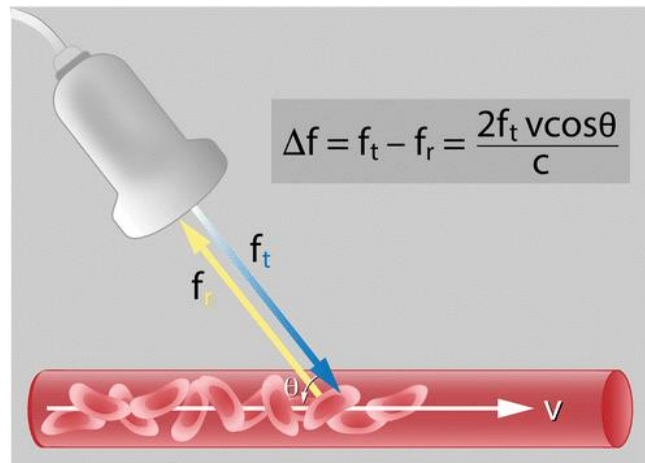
Visualization of Doppler frequency shift.³⁴
